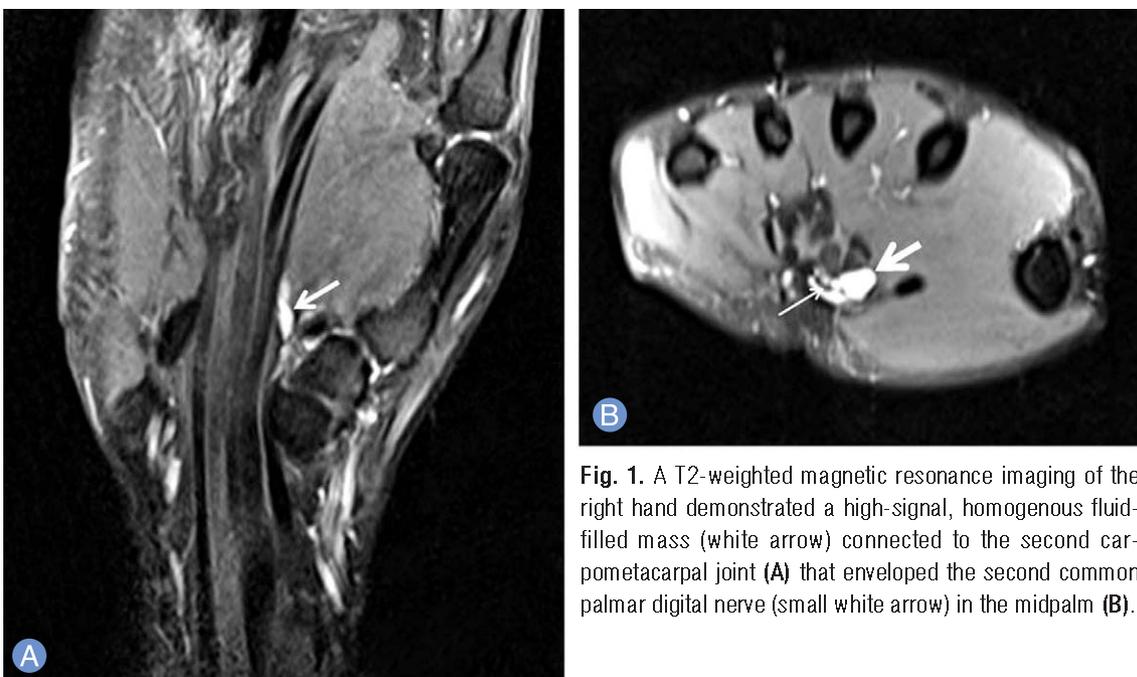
A T2-weighted magnetic resonance imaging of the right hand demonstrated a high-signal, homogenous fluid-filled mass (white arrow) connected to the second carpometacarpal joint (A) that enveloped the second common palmar digital nerve (small white arrow) in the midpalm (B).
